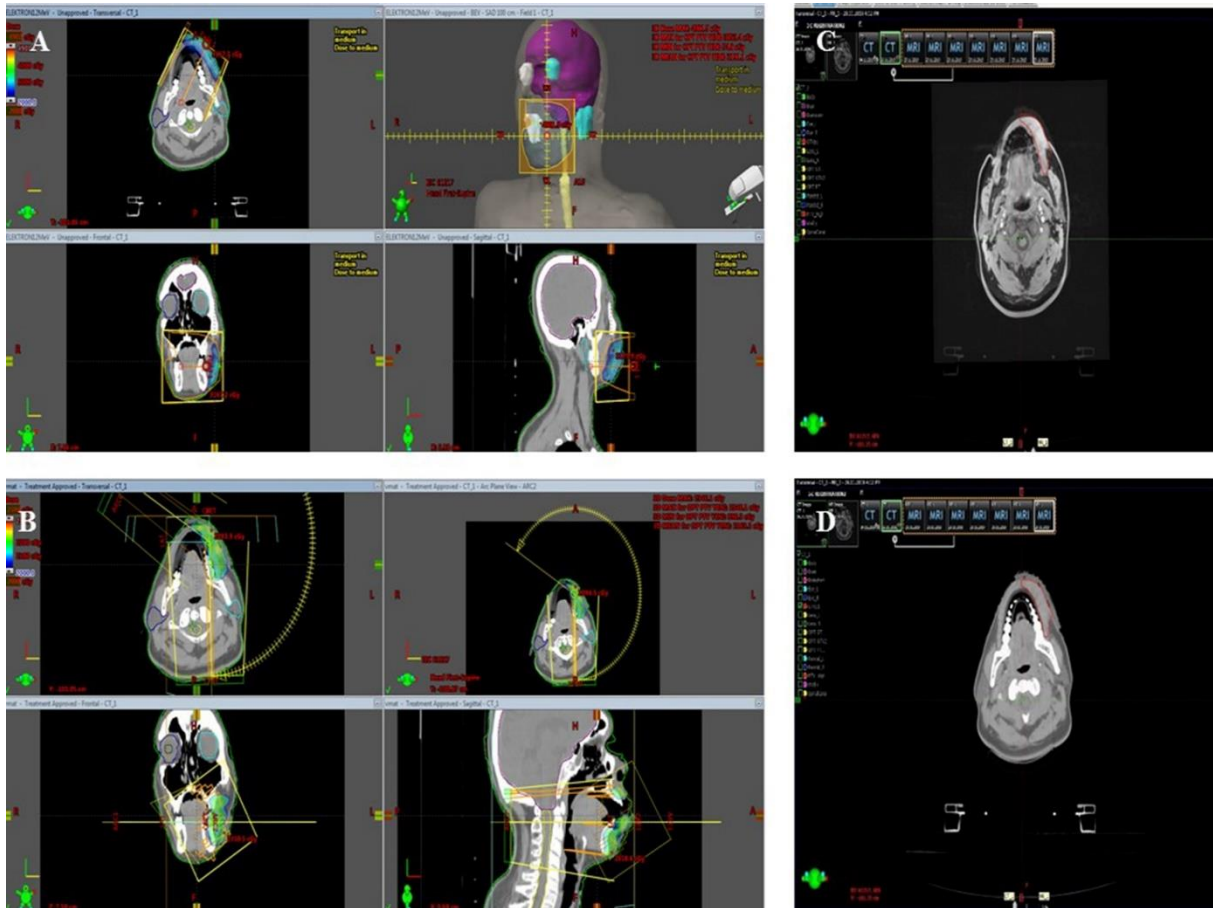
Radiotherapy dose and volume images of the patient. Planned radiotherapy with 12 MeV energy of 2016 (A). VMAT with 6 MV energy of 2019 (B). MRI-radiotherapy planning tomography fusion images used in treatment plans (C-D)
